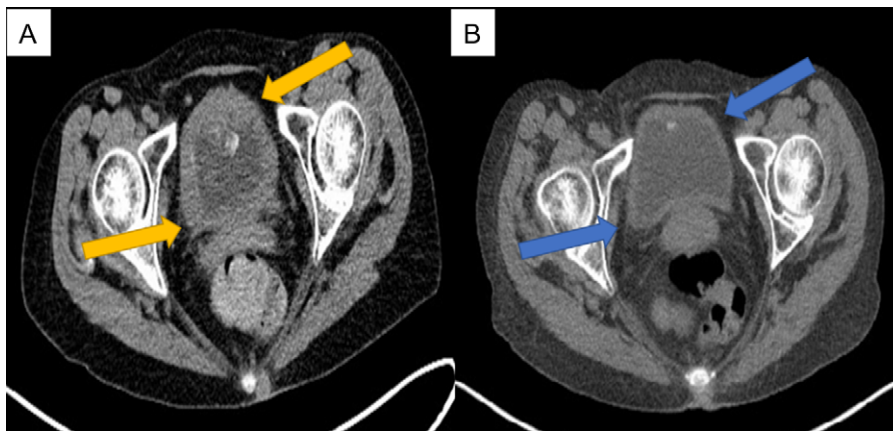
CT scan of the abdomen and pelvis pre-treatment image with yellow arrows (A) and post-treatment image with blue arrows (B) showing the resolution of the bladder wall thickening.
